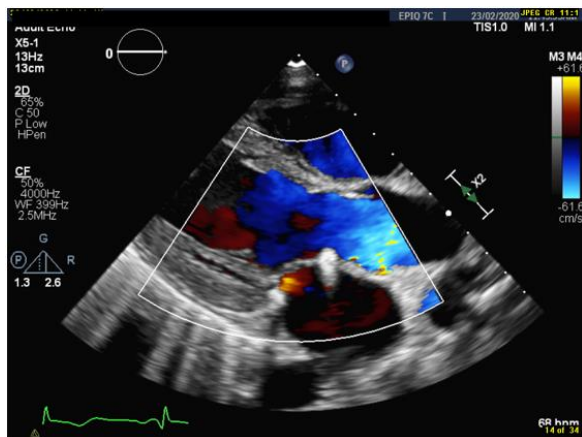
Transthoracic echo image indicating competent post-repaired mitral valve.
